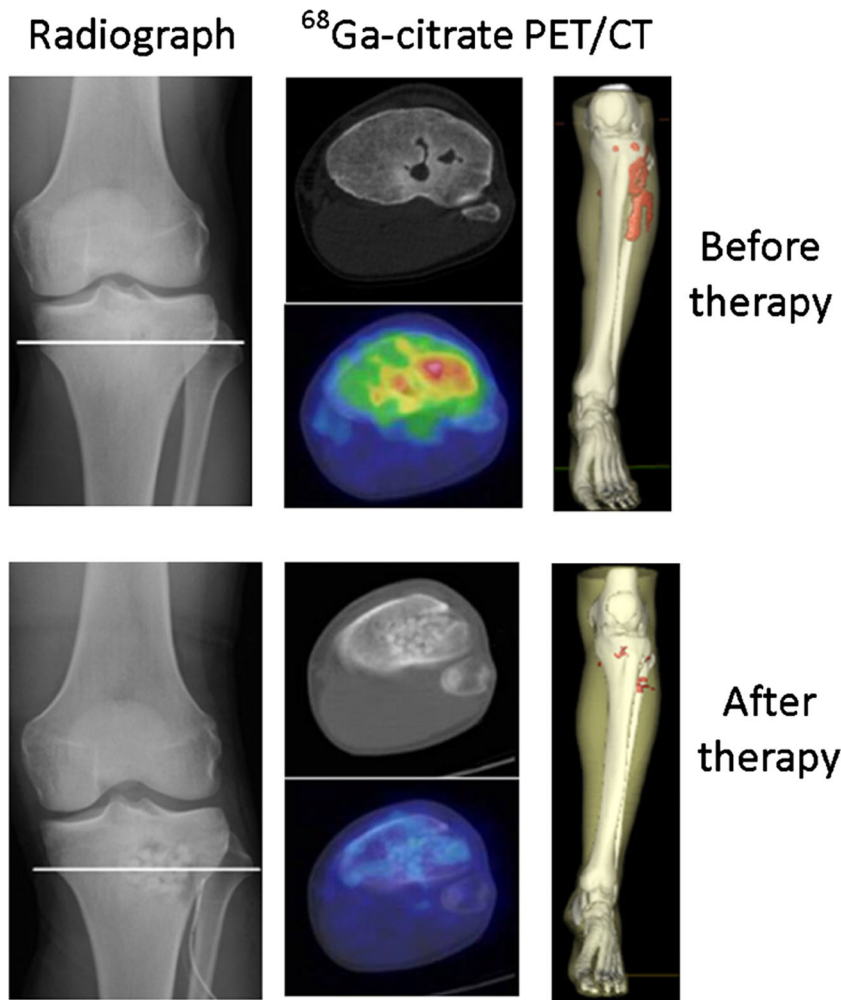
[^{68}Ga]citrate PET/CT images of a patient with acute osteomyelitis before and after operation. Significant uptake of the left fibula was observed prior to therapy. No obvious uptake after therapy was observed. This research was originally published in JNM. From Cristina *et al.* [31].
